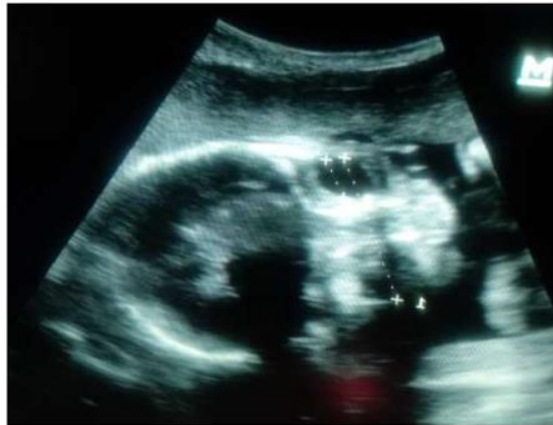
Pregnant women (27) years, Frontal ultrasound view shows binocular distance (4.25 cm) and ocular diameter (1.12 cm) in 31 week of GA
